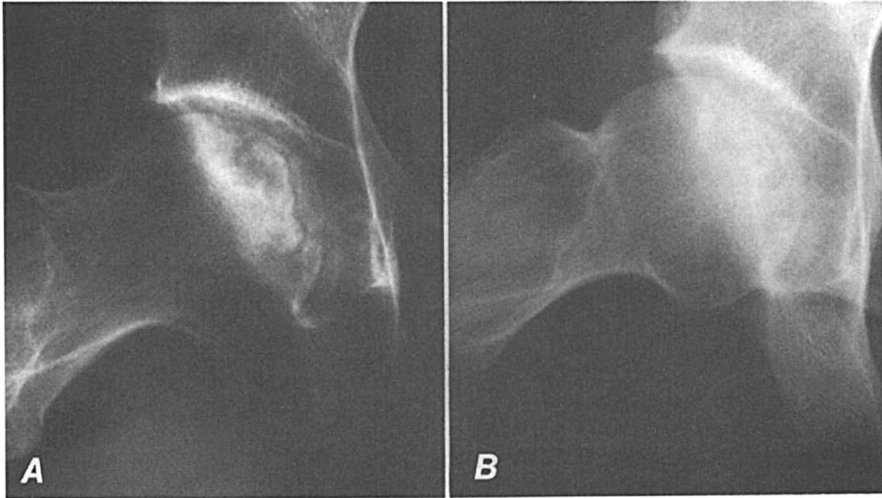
Side (lateral) X-ray of the hip in a 38-year-old patient with osteonecrosis probably secondary to cardiac steroid use. A: immediately before start of PEMFs, note the multiple gray lines (fractures) coursing through the “ball” (femoral head). Patient was disabled by pain. B: 1 year after PEMFs started, the patient was asymptomatic and fully active. Although some collapse occurred before treatment was instituted, it has caused no further pathologic change in the contour over the past 10 years since treatment was stopped.
